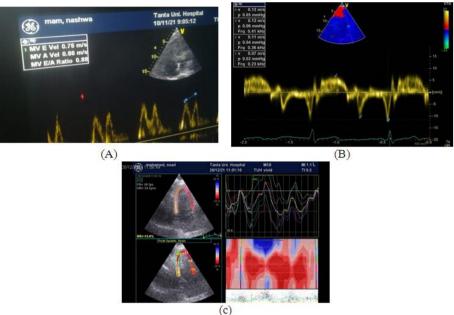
(A) Conventional echocardiography (B) Tissue doppler (E 0.76 m/s, A 0.86 m/s, E/A ratio 0.88, E/ e' 6.9, LAVI 31 ml/m2, (C) Speckle tracking echocardiography assessment of LV systolic function. Global longitudinal strain (LS). as mean of two (GS= -15.6%)
